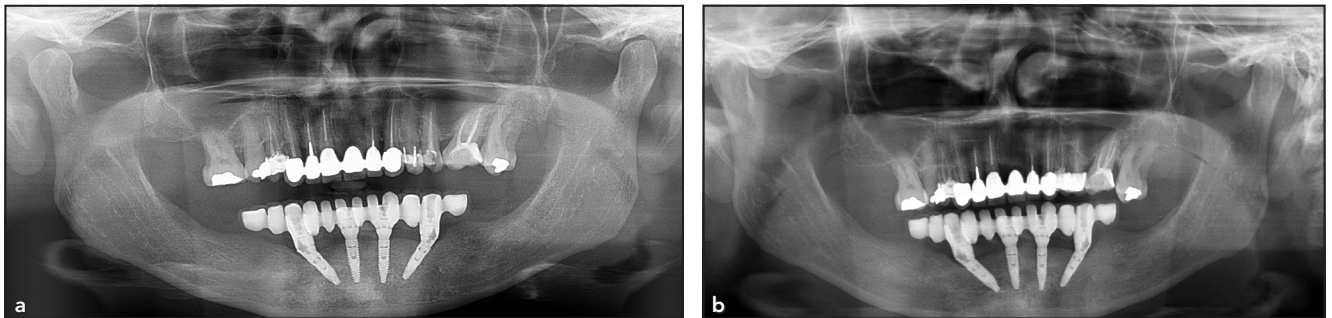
Representative radiographic views taken (a) after implant-prosthetic rehabilitation and (b) at the 3-year follow-up visit.
